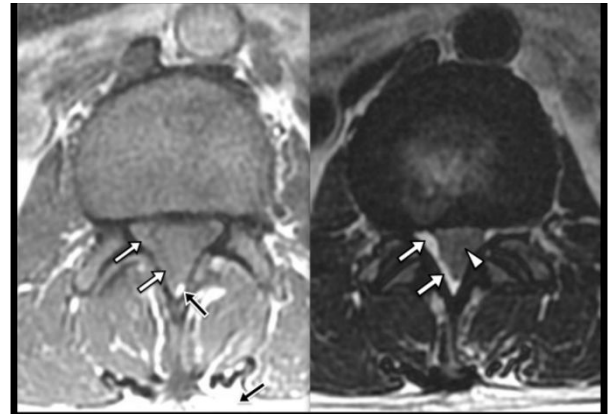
Magnetic Resonance Imaging- Axial T1 (left) and T2 (right) images obtained without fat saturation at the level of L1/L2 demonstrate severe spinal canal stenosis with a paucity of normal CSF signal within the subarachnoid space (arrowhead). An extradural T1 isointense and T2 hyperintense fluid collection (white arrows) compresses the thecal sac. The isointense T1 signal within the collection differs from the normal epidural fat and subcutaneous fat (black arrows).
